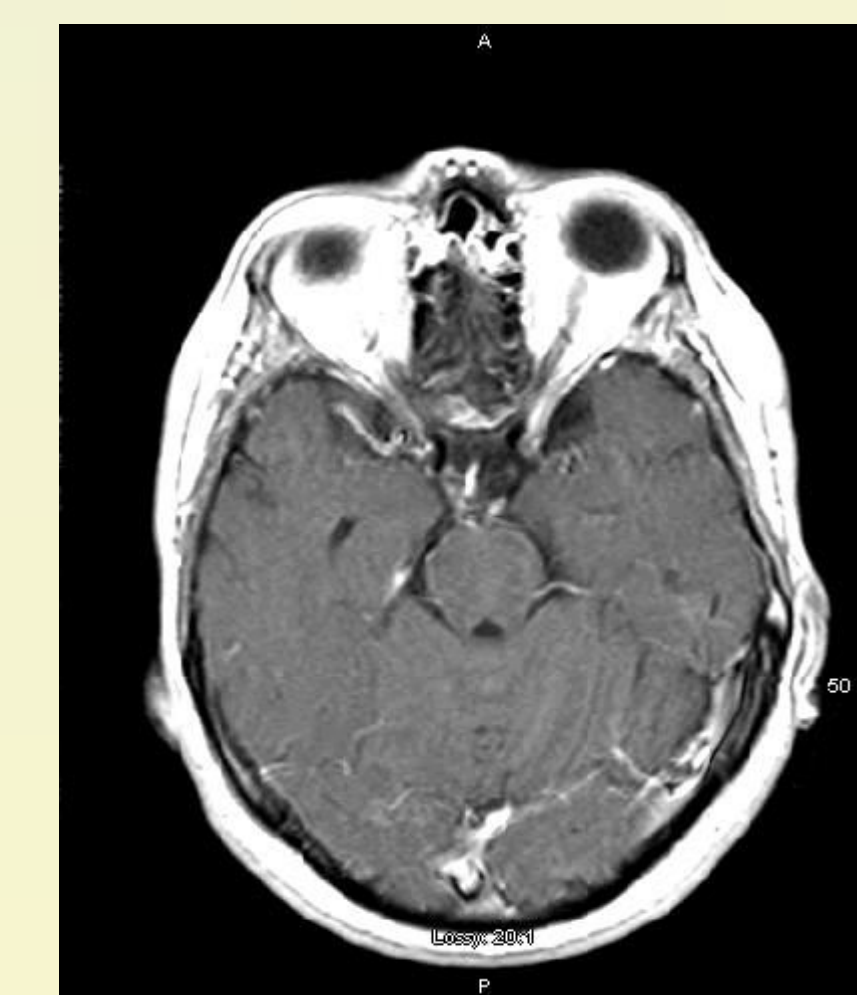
MRI T1 Axial + GAD showing resolution of suprasellar enhancing lesion. 5/2016
